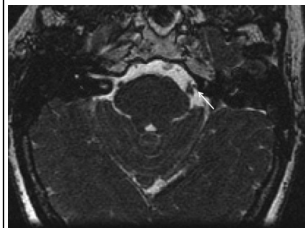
Fiesta T2 MRI showing compressive vessel loop (white arrow) adjacent to Trigeminal Nerve
